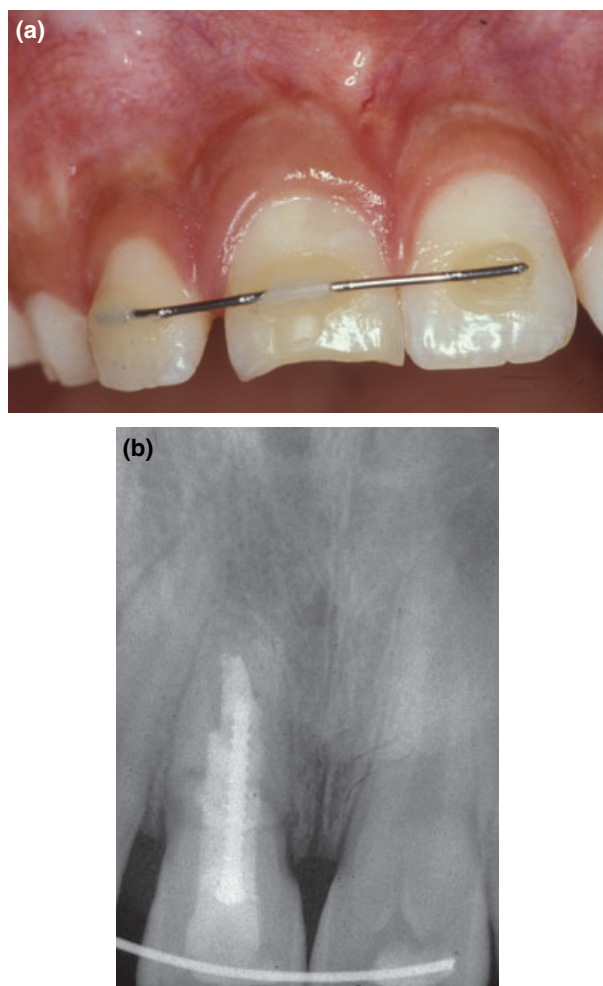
Clinical (a) and radiographic (b) control at 18-month follow-up.
